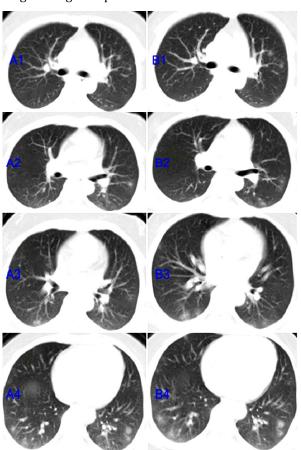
A1-4 shows the first chest computed tomography (CT) (no high-resolution CT) scan of a 32-year-old woman from Wuhan. The first CT scan was obtained 4 days after onset, and multiple ground-glass opacities can be observed around the lung. B1-4 shows the re-examination 2 days after anti-infective therapy with moxifloxacin. The increase in ground-glass opacities can be observed, and the nucleic acid examination of the novel coronavirus from a throat swab was positive.
